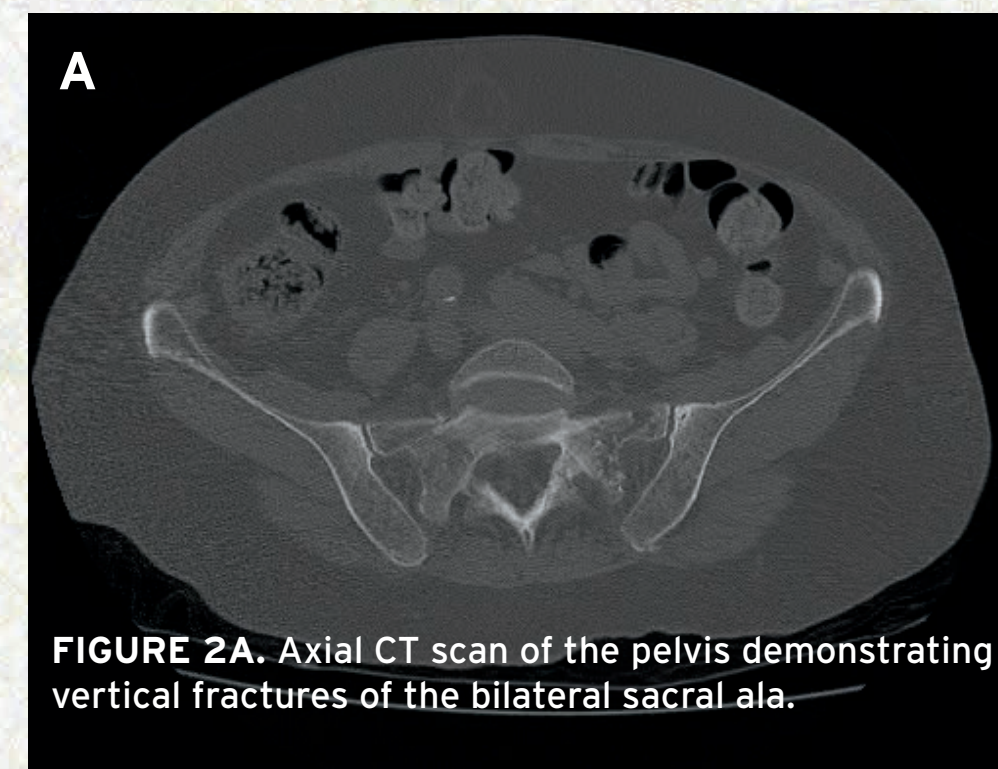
Axial CT scan of the pelvis demonstrating vertical fractures of the bilateral sacral ala.
